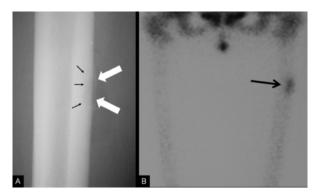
Radiograph (a) of the left femoral bone shows a thin periosteal reaction (white arrows) and an underlying lytic lesion (thin black arrows). Bone scan (b) shows a focal uptake on the proximal femoral diaphysis (thick black arrow).
